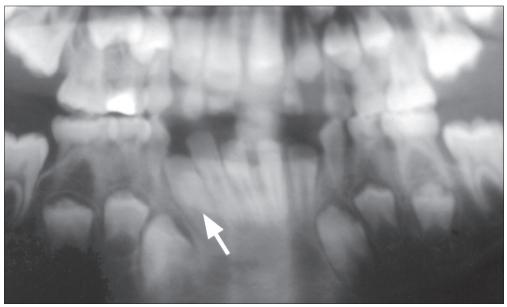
Panoramic radiograph—unerupted supernumerary lower incisor
